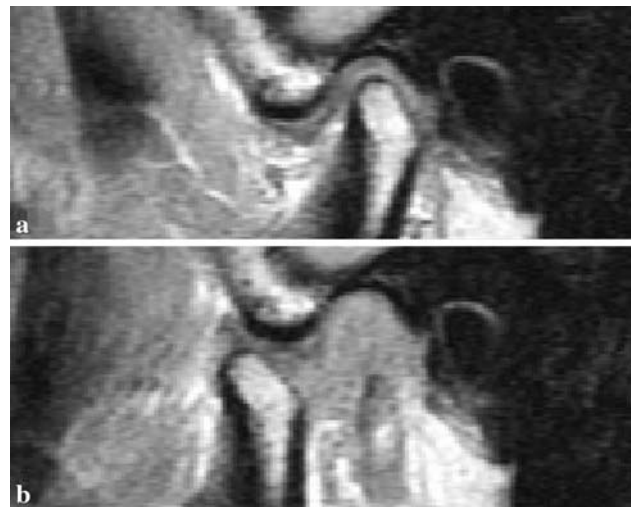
MRI of ADDwR: a closed and b open mouths
